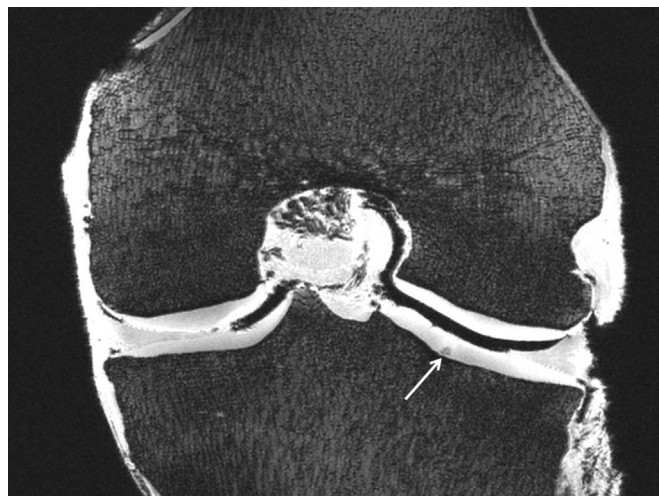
MRI of human knee joint showing evidence of a HDMP (white arrow).
